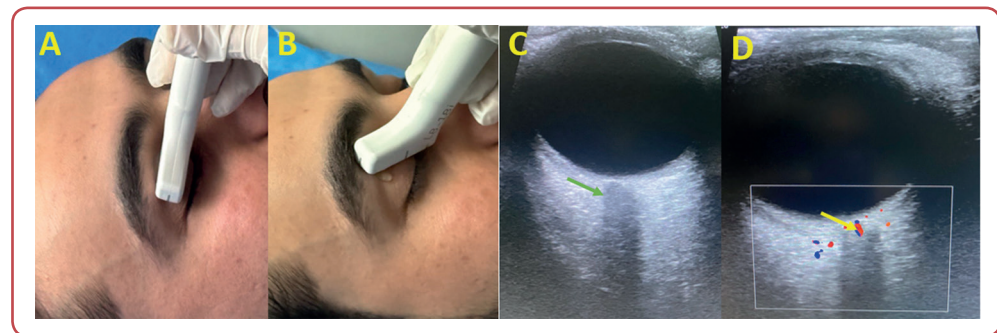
A) transverse position of the probe during ocular examination. B) longitudinal position of the probe. C) Ultrasound image of the eyeball (B-mode) for localisation of the optic nerve (green arrow). D) A flow Doppler sonographic image of the eyeball shows the central retinal artery (yellow arrow).
